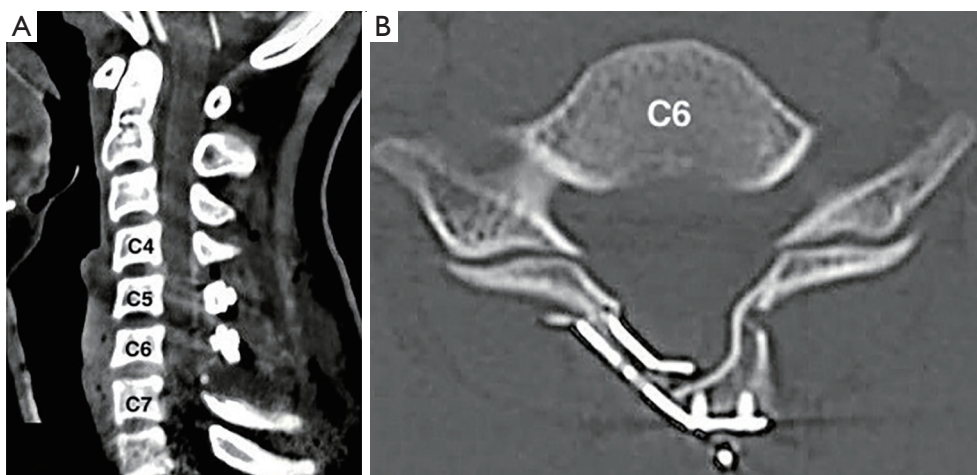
Post-operative CT scan. (A) Sagittal view; showed no residual hematoma in C4–C7. (B) Axial view of C6; laminoplasty using laminoplasty plates and well-decompressed spinal canal. CT, computed tomography.
